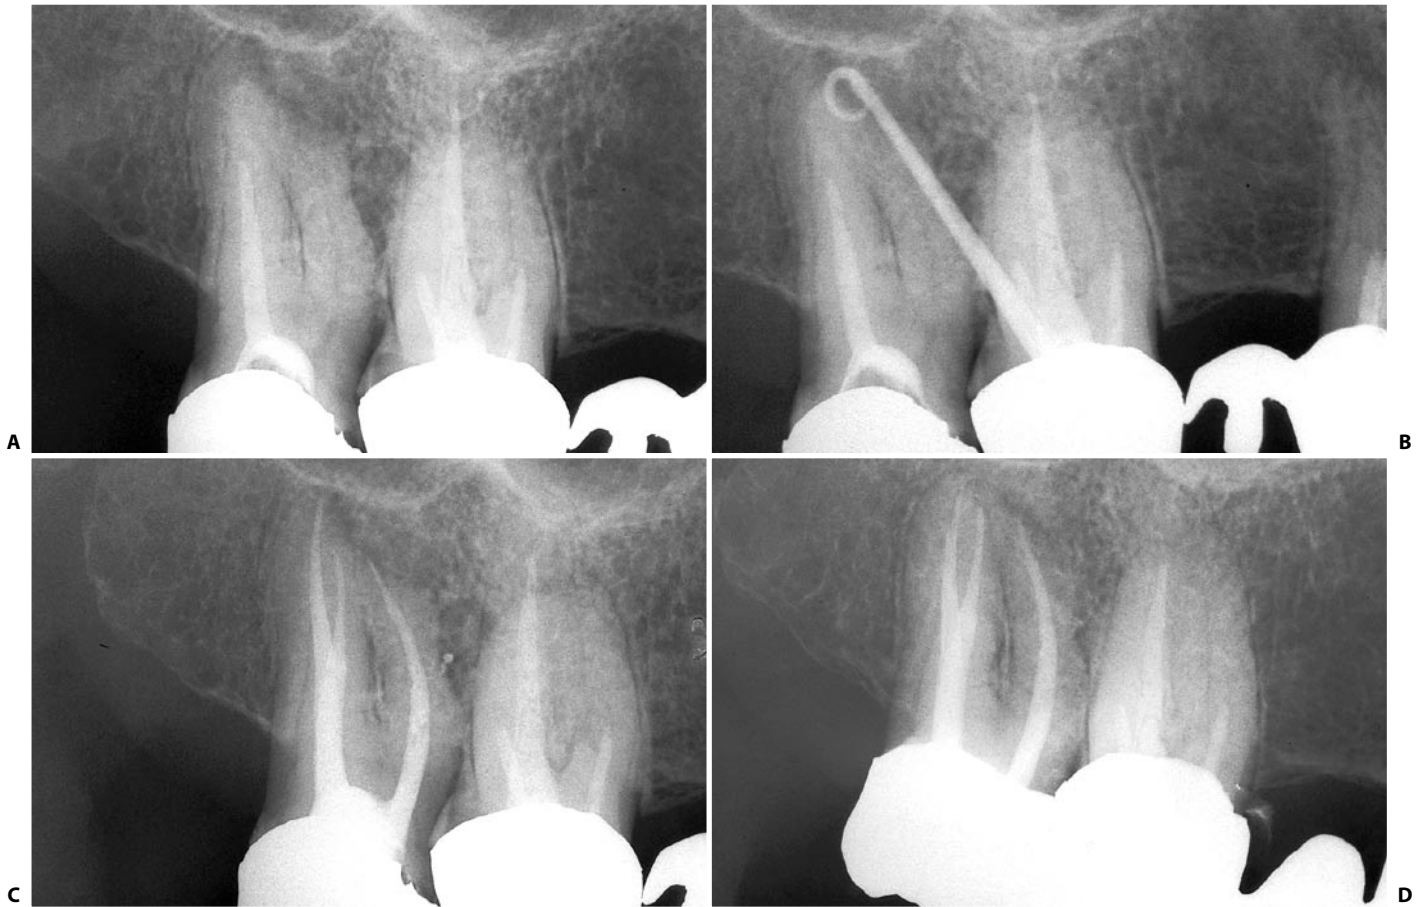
A. Preoperative radiograph of the upper right first and second molars. Note the round radiolucency between the mesiobuccal root of the second molar and the distobuccal root of the first. The patient had presented with a vestibular fistula at the level of the first molar, and for financial reasons only wanted to retreat the diseased tooth. B. A gutta-percha cone placed in the fistula indicates that the fistulous tract arises from the second molar. C. Postoperative radiograph of the second molar. Note that a small lateral canal in the mesiobuccal root, which was apparently responsible for the lesion seen in the preoperative film, has filled up. D. Five year recall.
